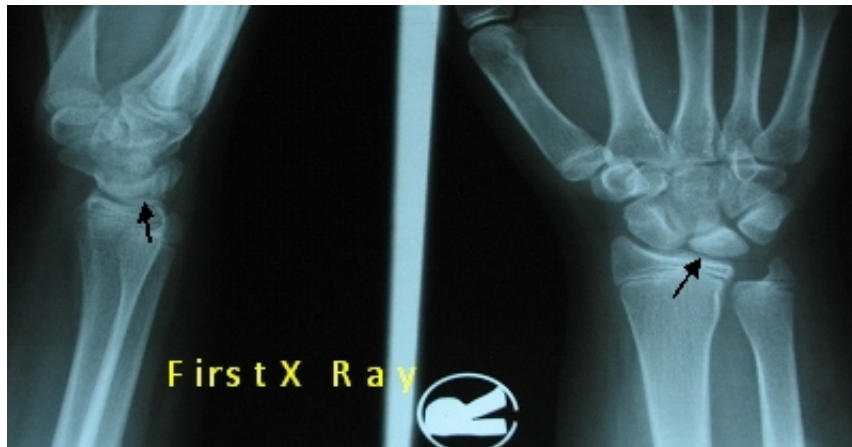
Radiographs showing sclerosis of lunate bone six months after the trauma.
